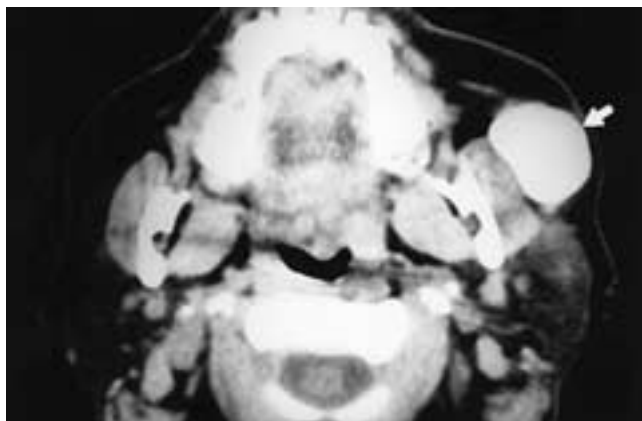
Axial CT scan taken after contrast injection into a cystic mass along the course of Stensen's duct (arrow). This patient had received trauma to this area of the cheek. The patient had a noncommunicating sialoceles.
